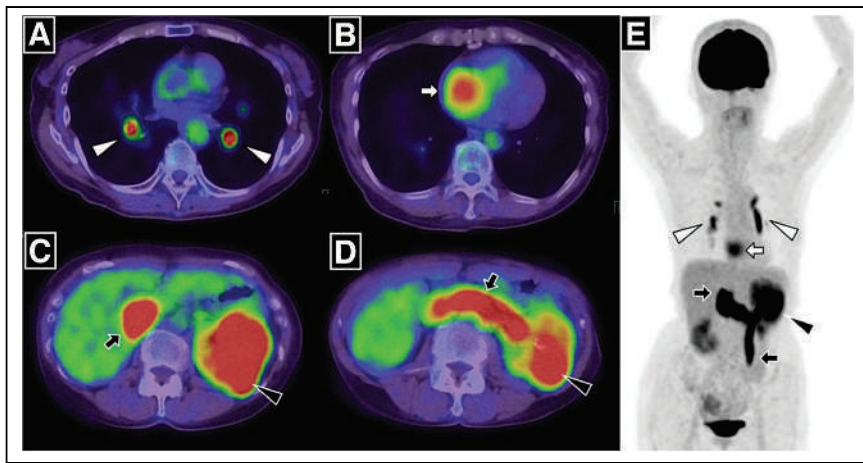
Massive pulmonary tumor emboli from intravascular tumor thrombus in patient with renal cell carcinoma. PET/CT and maximum-intensity-projection images demonstrate ^{18}F -FDG accumulation in left renal tumor, which was continuously observed in left renal vein and extended into infradiaphragmatic inferior vena cava and left ovarian vein (C, D, and E, black arrows). ^{18}F -FDG uptake in left distal pulmonary artery and right and left branches (A and E, white arrowheads) and right atrial cavity (B and E, white arrows) is also seen. (Reprinted with permission of (55).)
